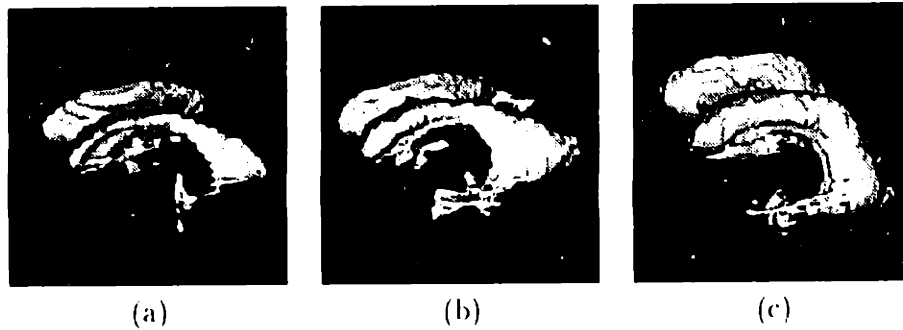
Reconstructions of the cerebral ventricles created from MR images. (a) Normal, healthy adult. (b) Patient with Alzheimer's disease. (c) Patient with normal-pressure hydrocephalus.
